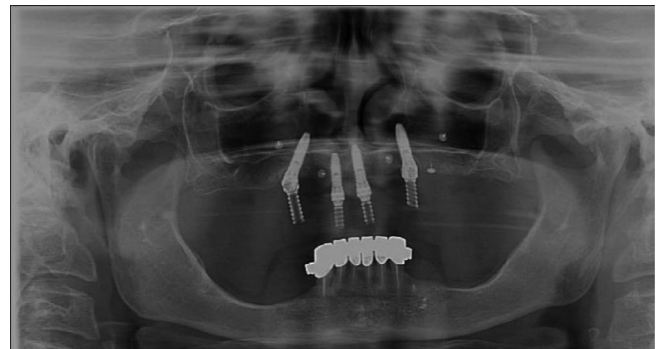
Panoramic radiograph showing the distribution of the maxillary implant along the arch.
